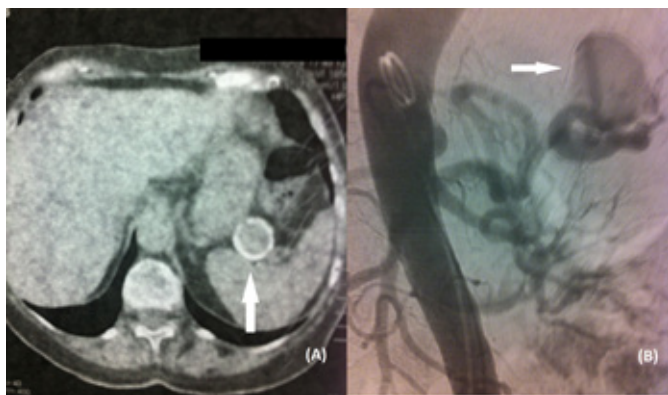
(A) Computed tomography angiography (CTA) of case 5 showing an atherosclerotic aneurysm of the splenic artery. (B) Digital subtraction angiography (DSA) of the same patient showing the aneurysm (arrow) at the splenic hilum as well as the tortuosity of the splenic artery.
